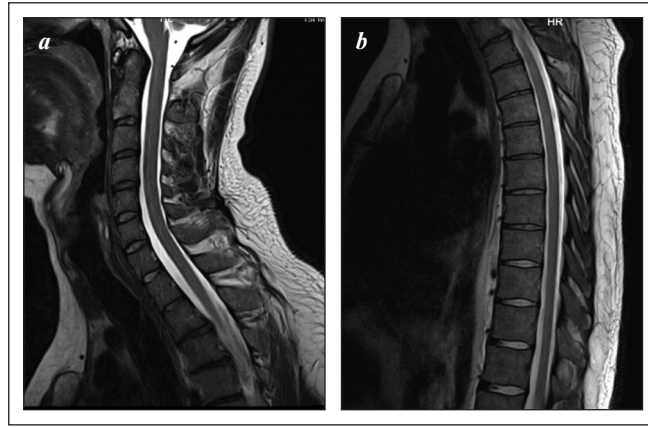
Cervical and thoracic spine MRI, T2 weighted image(a, b): no signs of focal lesions
